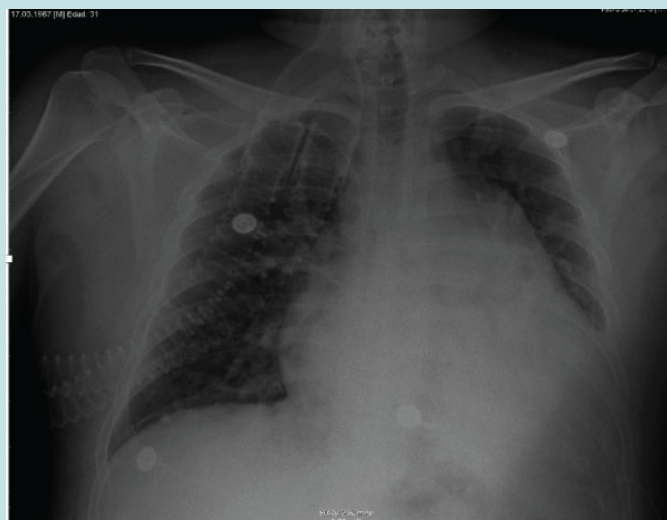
Chest X-ray with cardiomegaly, prominent bilateral pulmonary branches and venocapillary hypertension.
